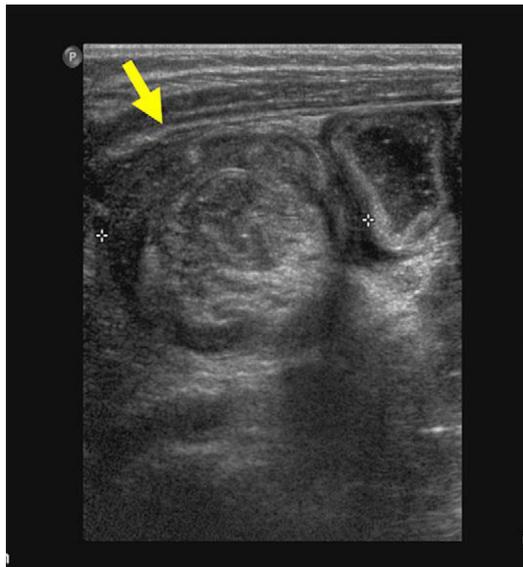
Sonographic image showing the target or donut sign associated with intussusception. (From Marin J, Alpern E. Abdominal pain in children. *Emerg Med Clin North Am* 2011;29:401–28.)
